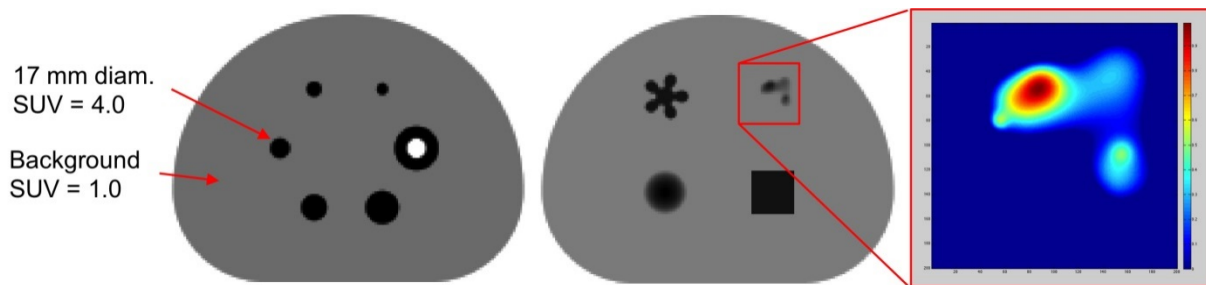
Two sections through the PET-MTV-DRO. All objects are three dimensional, and one object as indicated has variable SUVs.
